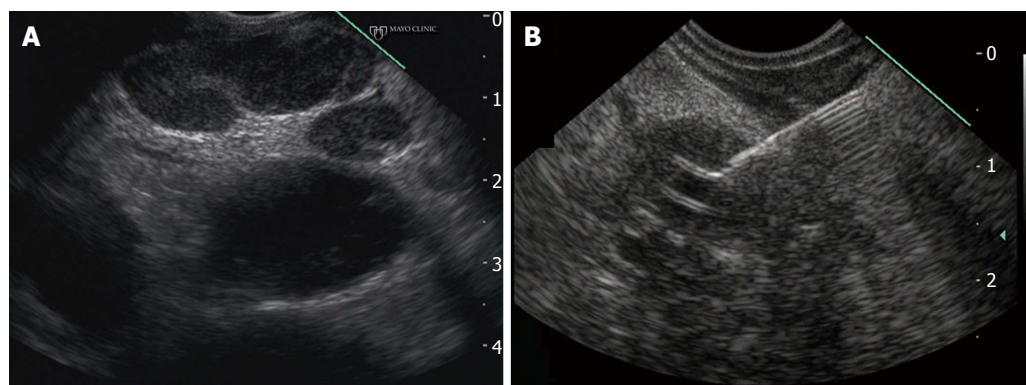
Endoscopic ultrasonographic findings in a patient found to have locally-advanced cholangiocarcinoma. A: Malignant lymphadenopathy; B: Endoscopic ultrasound-guided fine needle aspiration of primary cholangiocarcinoma.
